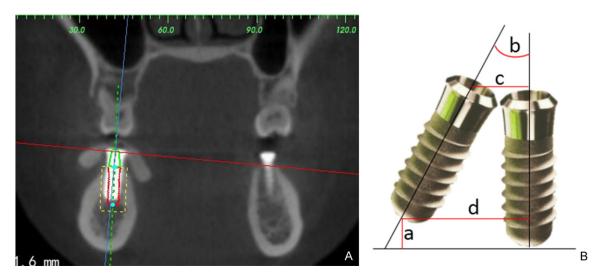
Measurement of implant deviation before and after implantation. A: Comparison of planned implant position designed by Tooth-Implant digital guide before implantation with the actual postoperative implant CBCT image of the same patient. B: Based on the ideal implant position designed by the Tooth-Implant digital guide software, a vertical line was drawn from the actual implant position to the ideal position to measure the differences in implant depth, angle, shoulder, and apex before and after implantation. a: The difference in depth before and after dental implantation; b: The difference in angle before and after dental implantation; c: The difference in shoulder before and after dental implantation; d: The difference in the apex before and after dental implantation.
